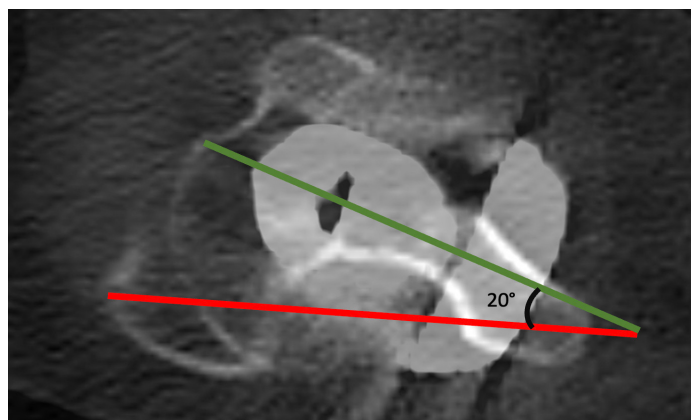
Measurement of humeral component retroversion using axial humerus CT slices; Red line intracondylar axis, green line humeral component axis
